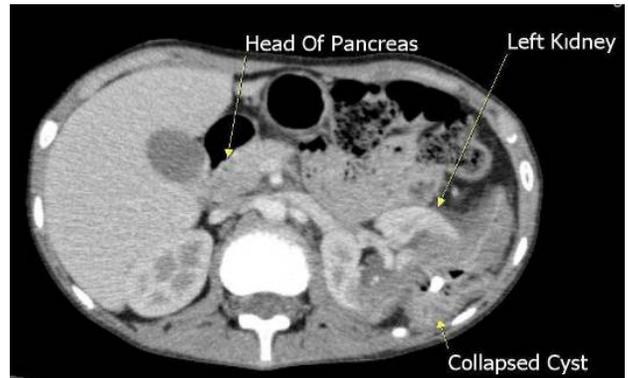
Post contrast abdominal computed tomography shows, normal pancreas and peripancreatic
